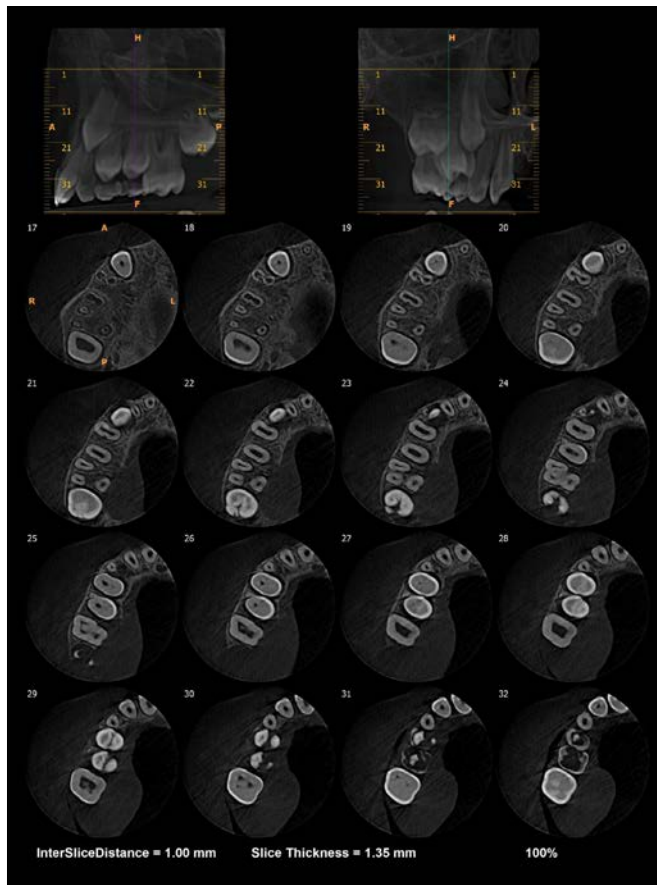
CBCT scan of sectional maxilla revealed no bony involvement.
